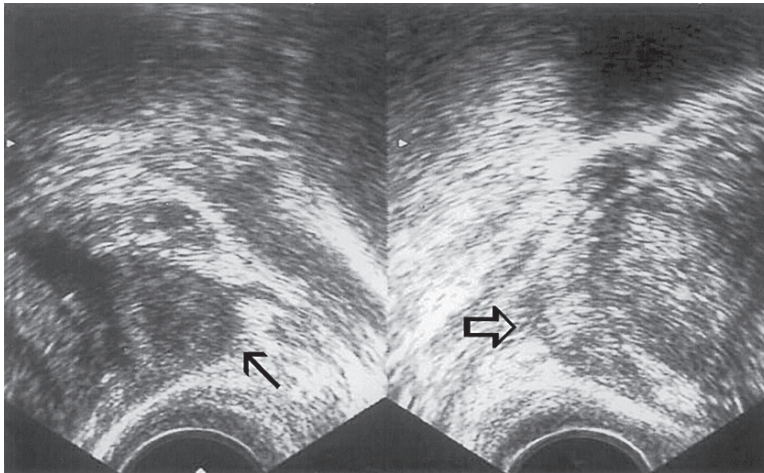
Transverse transrectal ultrasound scan showing a diffusely heterogenous echotexture of the peripheral zone at the left mid-prostate that was proven to be cancer (arrow). Note that the parenchyma of the peripheral zone on the contralateral side is homogeneously isoechoic, representing benign tissue (open arrow)
